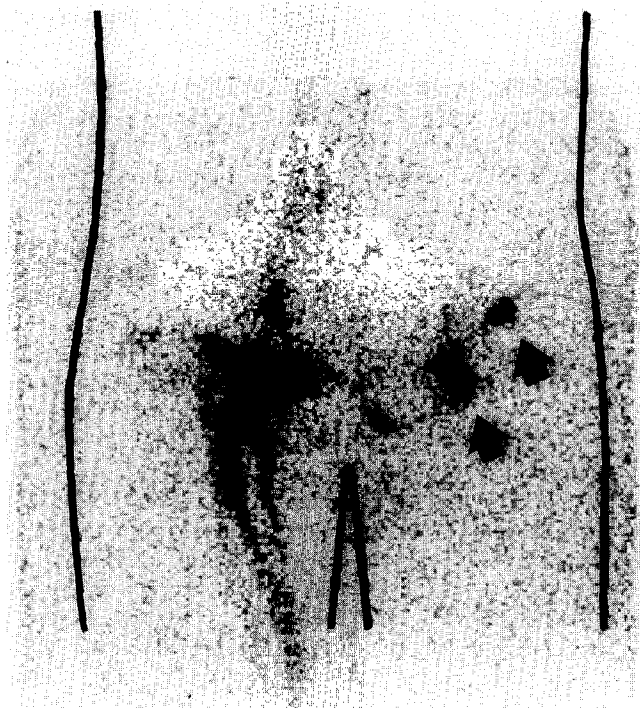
Initial lymphoscintigram image after intradermal injection of technetium-labelled antimony trisulphide colloid around primary melanoma site on calf, showing two lymphatic channels in the right thigh and trans-pubic drainage to sentinel nodes (arrowed) in the left groin.
